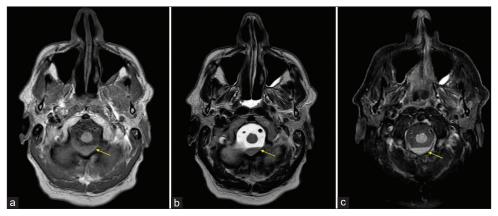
Axial MRI of the foramen magnum showing dependent blood products. (a) T1-weighted imaging. (b) T2-weighted imaging. (c) T2-FLAIR sequenced imaging. The yellow arrows indicate the blood products lying in the spinal canal. This was thought to have migrated from another site of bleeding, during our patient's period of recumbency. MRI: Magnetic resonance imaging, T2-FLAIR: T2-weighted fluidattenuated inversion recovery.
